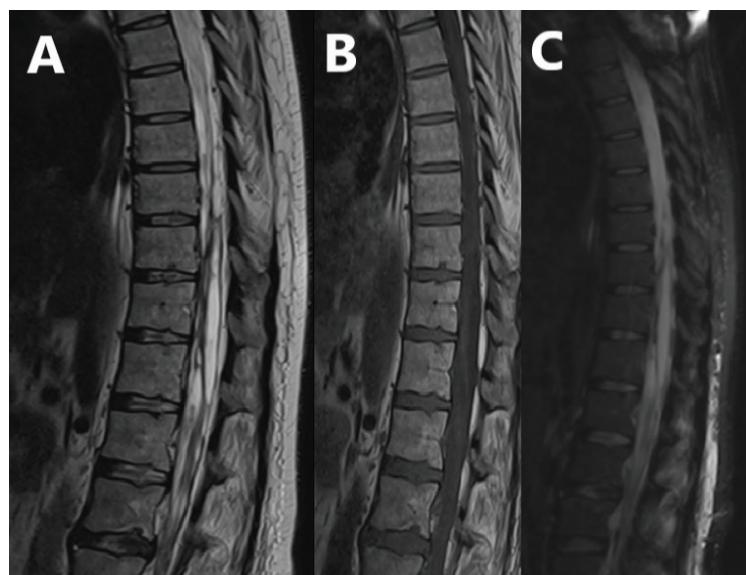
(A, B and C). MRI of the thoracic spine. Panel A shows T2 sequence with heterogeneous characteristic of tumor process, presence of hyperintense liquoroequivalent cysts. Panel B represents a sagittal section in T1 sequence. Panel C represents thoracic spine in tirm T1 sequence with signal suppression by adipose tissue
